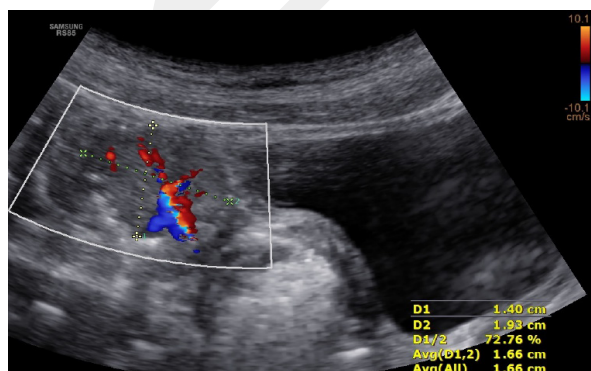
Patient No. 4. Abdominal ultrasonography revealed a solitary, well-vascularised round structure measuring 14 × 19 mm in the distal sigmoid colon
